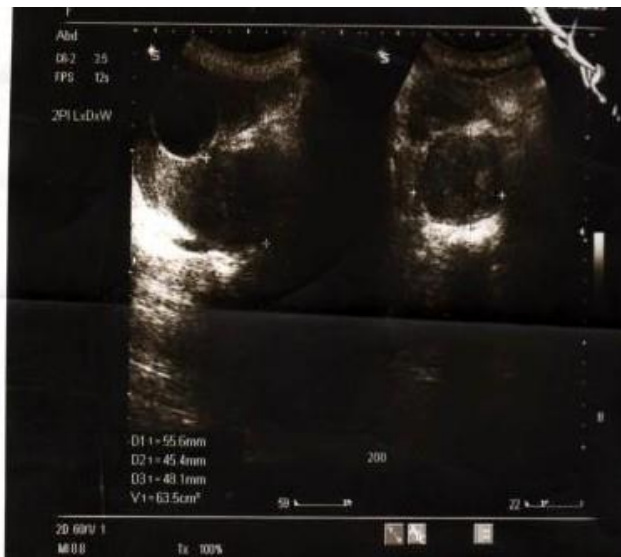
ultrasound image of PBH and post void residual urine in 70 years old man
